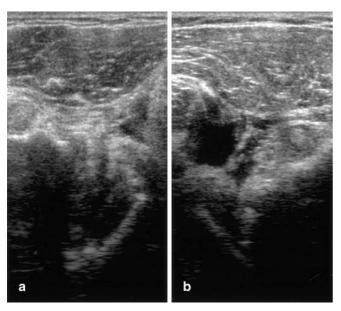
Axial sonograms obtained on the anterior aspect of left (a) and right (b) shoulder
